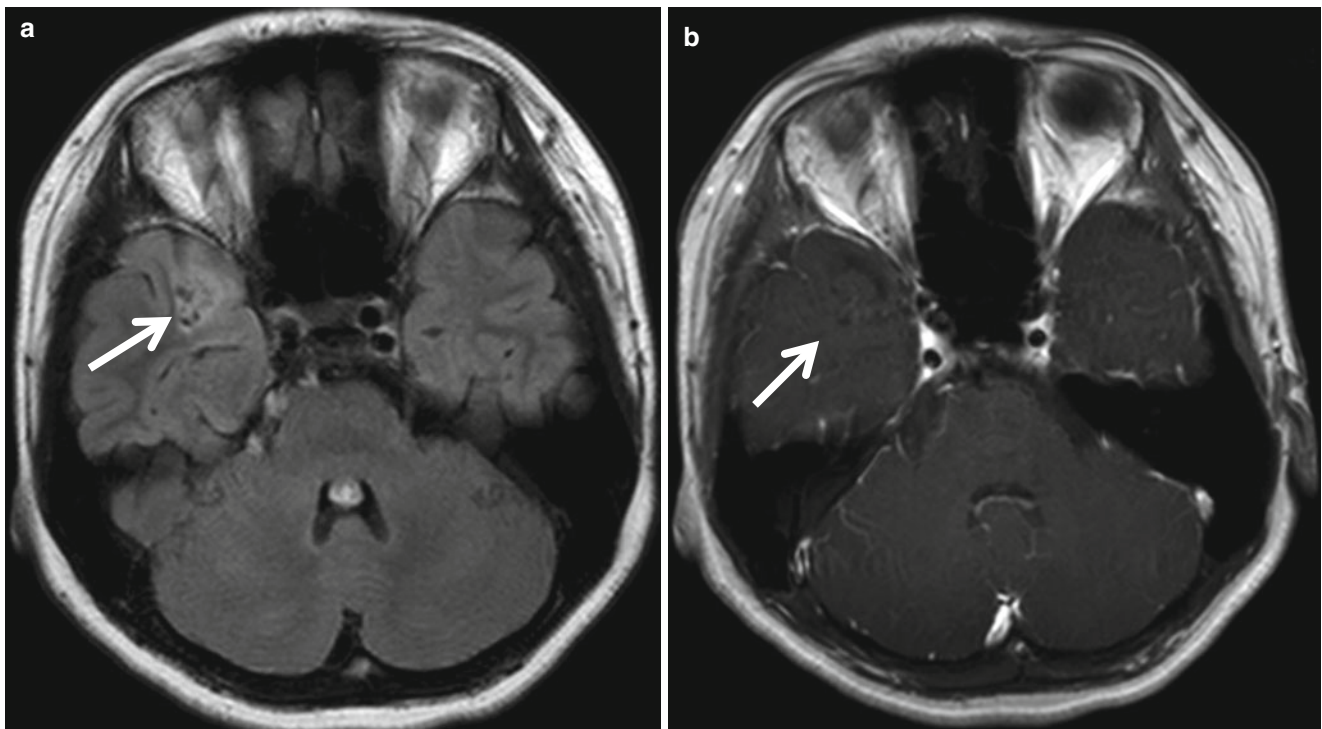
Dysembryoplastic neuroepithelial tumor (DNET) associated with adjacent focal cortical dysplasia in a 14-year-old girl. (a) FLAIR image shows localized high-intensity lesion containing multiple tiny
